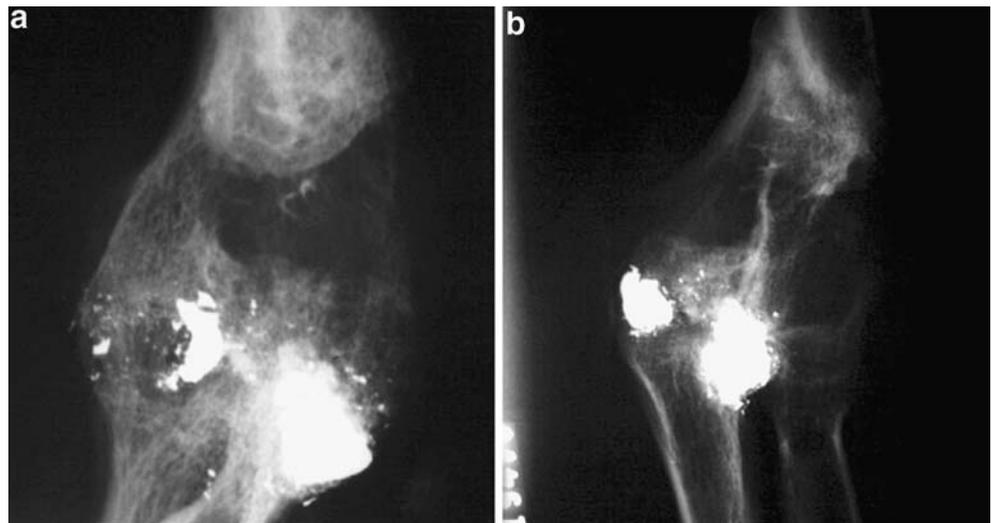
Plain radiographs of the right elbow (case 11) shows a fragmented bullet and particles of lead inside the joint. The joint space is asymmetrically reduced. The lead fragments do not assume the configuration of an arthrogram
